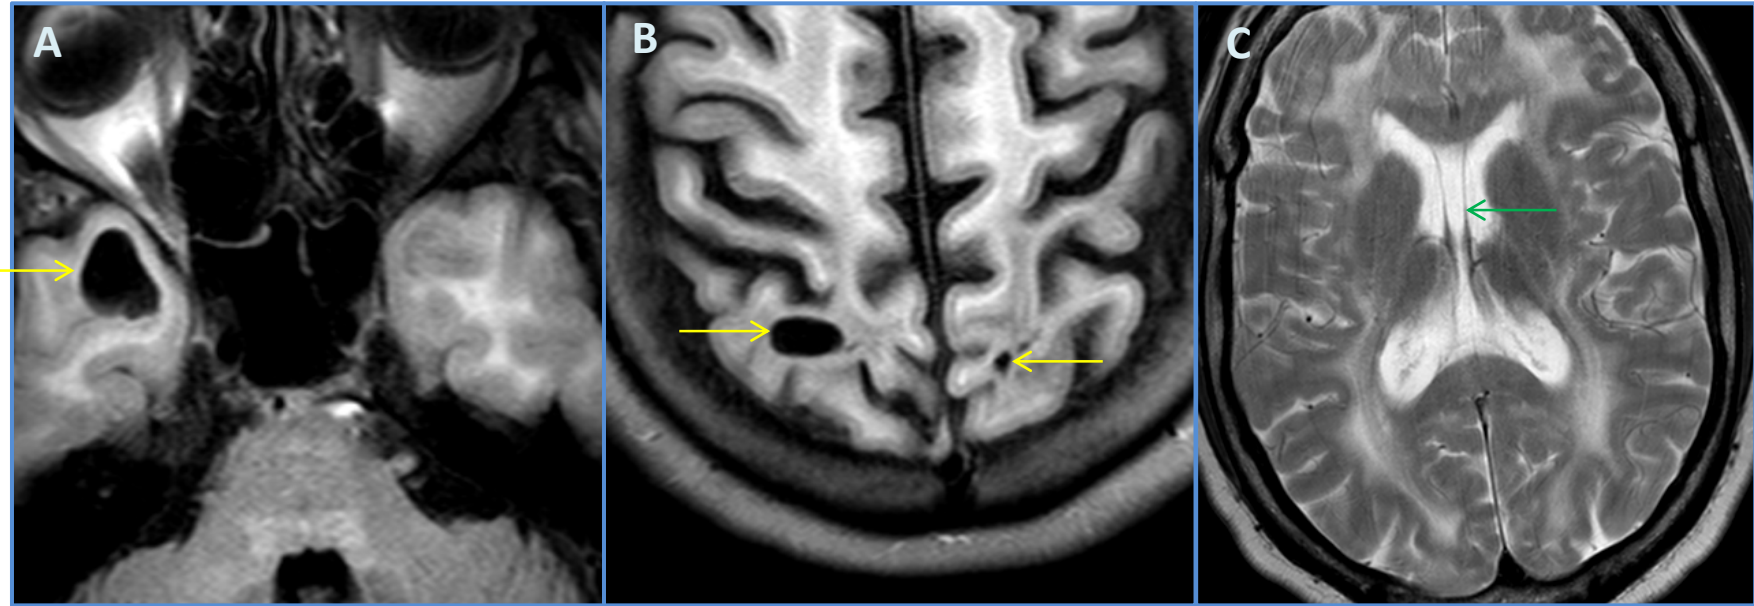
Axial FLAIR images (A) through the anterior temporal poles and (B) superior frontoparietal convexities showing subcortical cysts (yellow arrows). Axial T2 (C): the patient also has a cavum septum pellucidum et vergae (green arrow). Note also the extensive confluent white matter hyperintensity in all 3 images.
